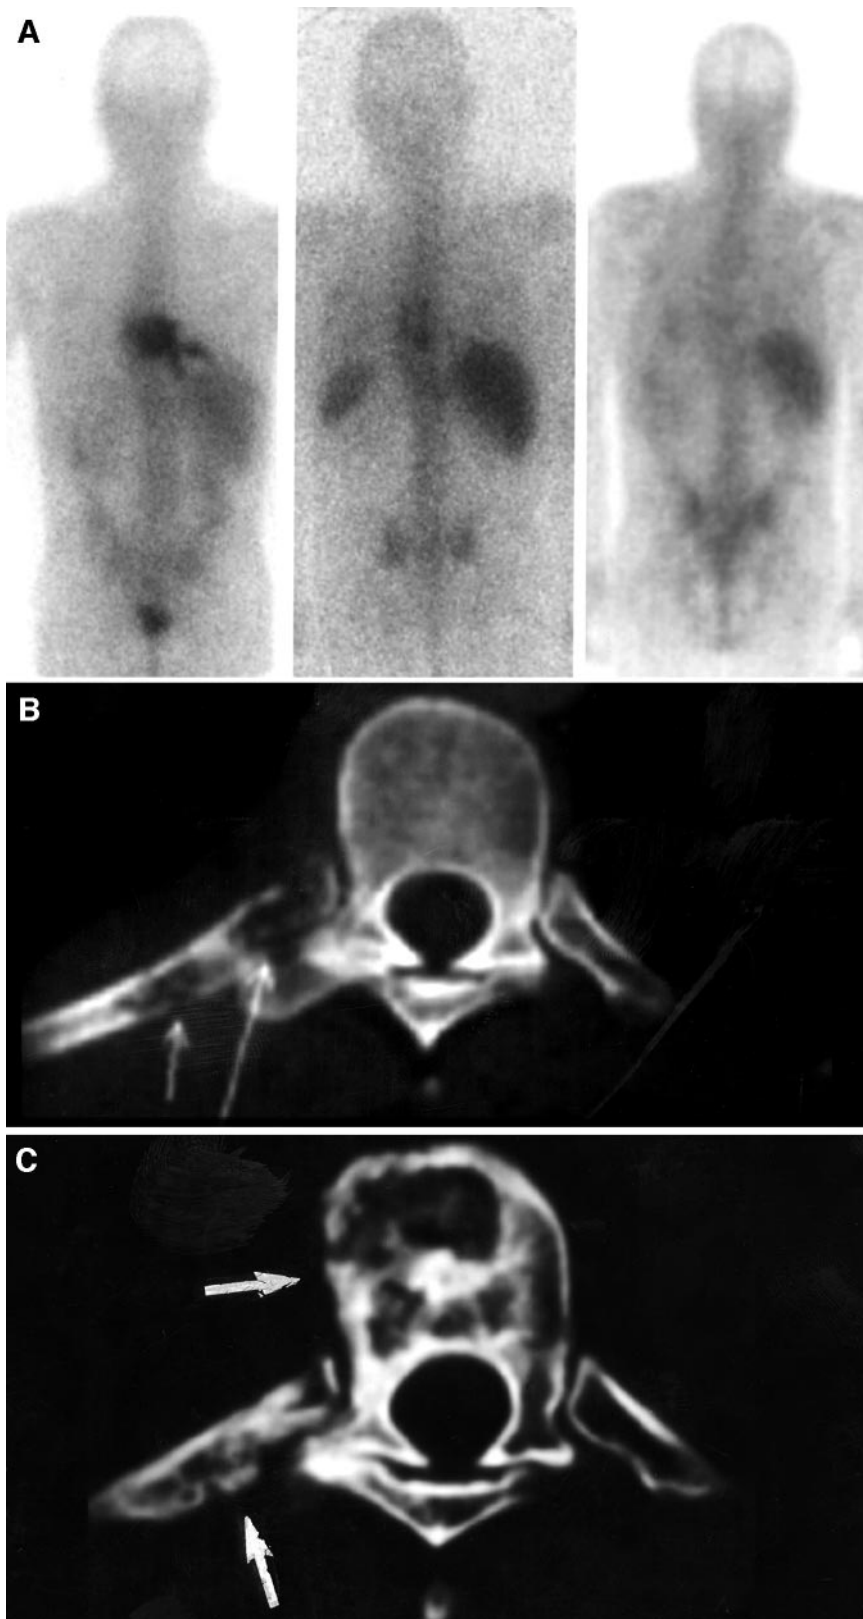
Negative ^{67}Ga scintigraphy and abnormal CT findings at end of treatment in 37-y-old man with diffuse large cell B-type NHL, stage I EA, involving posterior arch of 9th and 10th right ribs and T9 and T10 vertebrae. (A) ^{67}Ga scintigraphy at diagnosis (left) shows pathologic uptake at involved sites of disease. Marked improvement is seen at mid treatment (center), with residual abnormal ^{67}Ga activity in lower thoracic spine. ^{67}Ga scintigraphy findings at end of treatment (right) are negative. (B) CT at diagnosis shows infiltrative osteolytic lesion with cortical disruption of posterior arch of 9th right rib (arrows) and surrounding soft-tissue involvement. Moth-eaten pattern is seen in vertebral body of T9. (C) CT at end of treatment shows mixed sclerotic and lytic pattern in 9th rib and T9 vertebral body (arrows). Patient had no evidence of disease for 30 mo.
